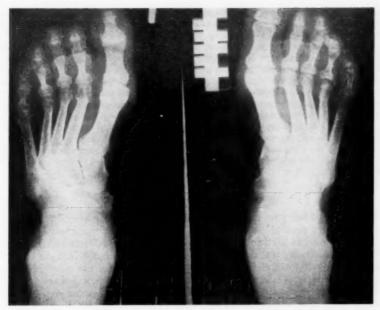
Roentgen-rays of feet, interpreted as normal by radiologist.
